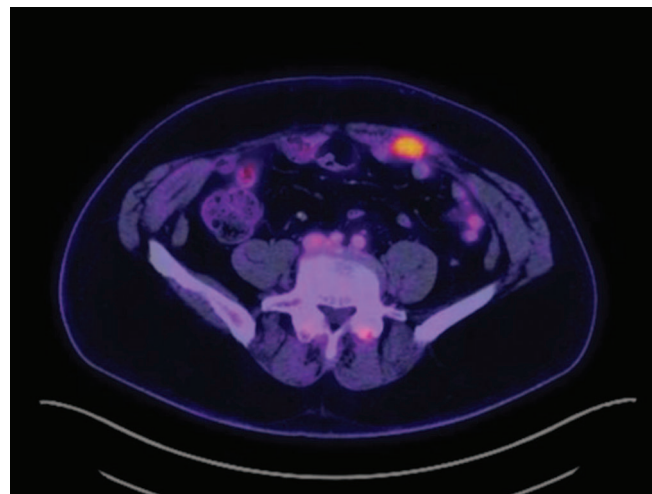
Positron emission computed tomography scan. The figure demonstrates a hypermetabolic lesion in the left rectus musculature. Core needle biopsy confirms this to be adenocarcinoma of colon primary.
